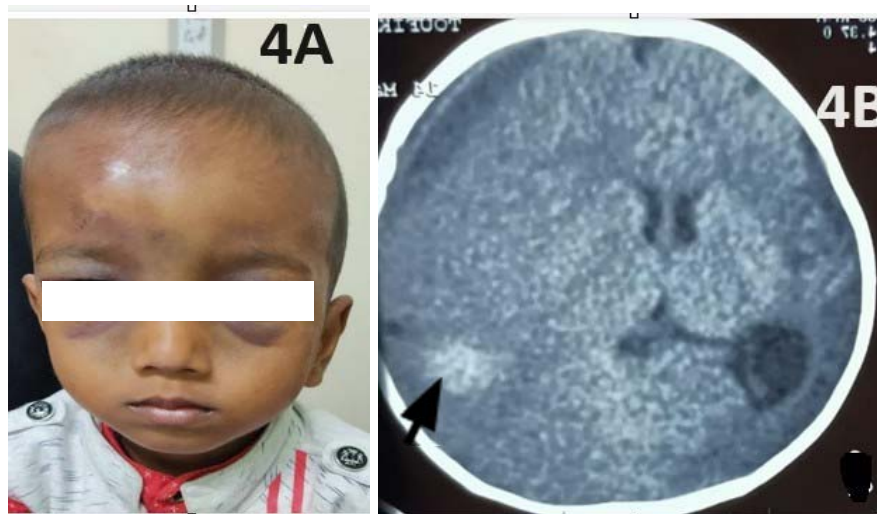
(a,b): (a) Racoon eye at presentation of a case of severe haemophilia and (b) CT scan shows CNS bleed in the right parietal
